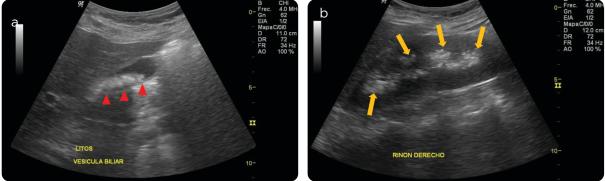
Ultrasound of upper abdomen. a) Longitudinal section of the gallbladder: multiple hyperechoic images with posterior acoustic shadowing in the gallbladder. b) Lateral view of the right kidney longitudinal axis: multiple hyperechoic images in the medullary region of the kidney confined to the renal pyramids.
